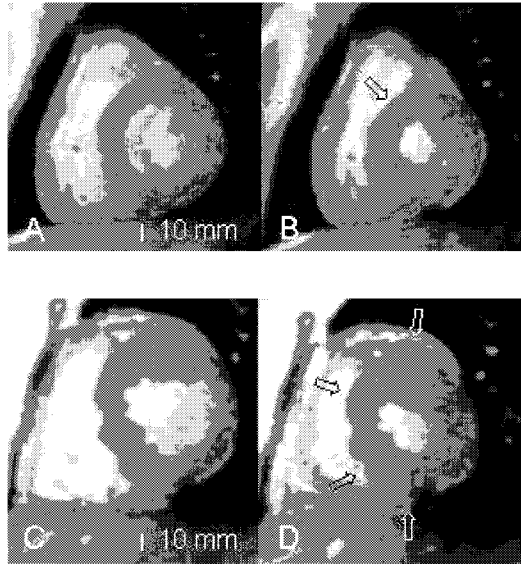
The short axis end-diastolic (A) and end-systolic (B) LV cine MR images (TR msec/TE msec, 60/4.8; FA 20°) in a 23-year-old man with the TPM1-Asp175Asn. The patient had mild LVH and only one hypokinetic segment (anteroseptal segment at basal level; arrow). Corresponding images (C, D) in a 22-year-old man with the TPM1-Asp175Asn and marked LVH and several hypokinetic segments (arrows). All cine images are shown as movies on web site: <http://radiology.rsnajnlis.org/cgi/content/full/2363041165/DC1>
